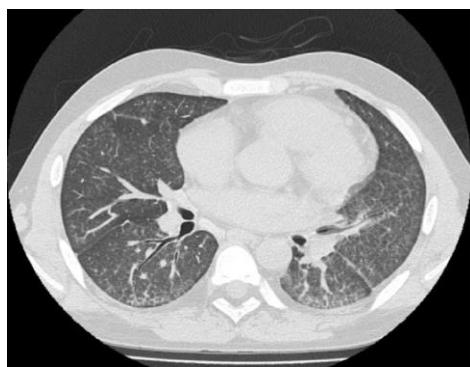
High-resolution chest CT imaging showing crazy pavement pattern of interstitial thickening and bilateral diffuse ground glass opacities involving bilateral lower lobes
